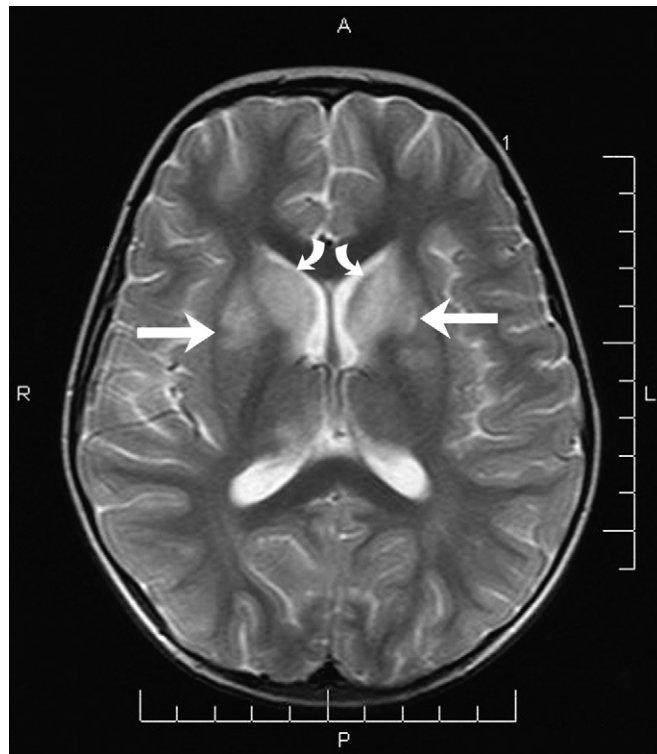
ADEM. Axial T2-weighted MR image shows symmetric increased signal in the head of the caudate nucleus (*curved arrows*) and anterior lentiform nuclei (*straight arrows*) associated with ADEM.
